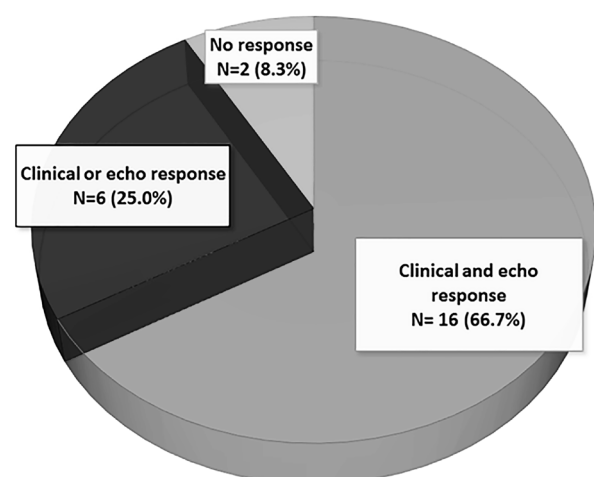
Pie chart showing the clinical versus echocardiographic parameters (LVEF and/or LVESV) to assess response to CRT. CRT: Cardiac resynchronisation therapy; LVEF: Left ventricular ejection fraction; LVESV: Left ventricular end-systolic volume
